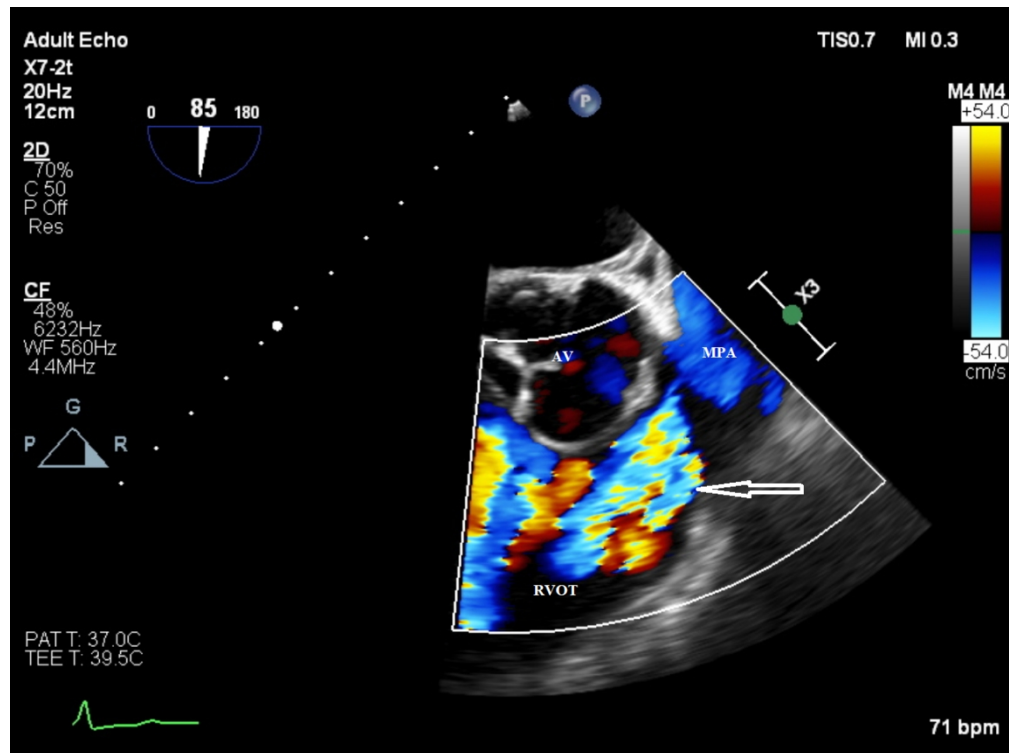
Mid-oesophageal long axis view of the pulmonary valve from a transoesophageal echocardiogram using colour Doppler to demonstrate severe pulmonary regurgitation (indicated by the arrow) that could not be identified in a 73-year-old ex-smoker with limited transthoracic acoustic window. AV=aortic valve; RVOT=right ventricular outflow tract; MPA=main pulmonary artery.
